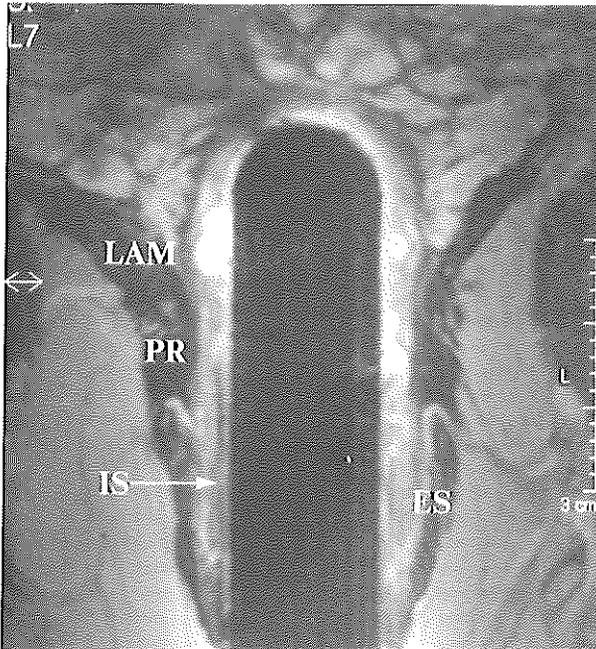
Endoanal MRI, coronal T2w TSE of a normal sphincter complex. External sphincter (ES). Puborectalis (PR) and levator ani muscles (LAM). Internal sphincter (IS).
